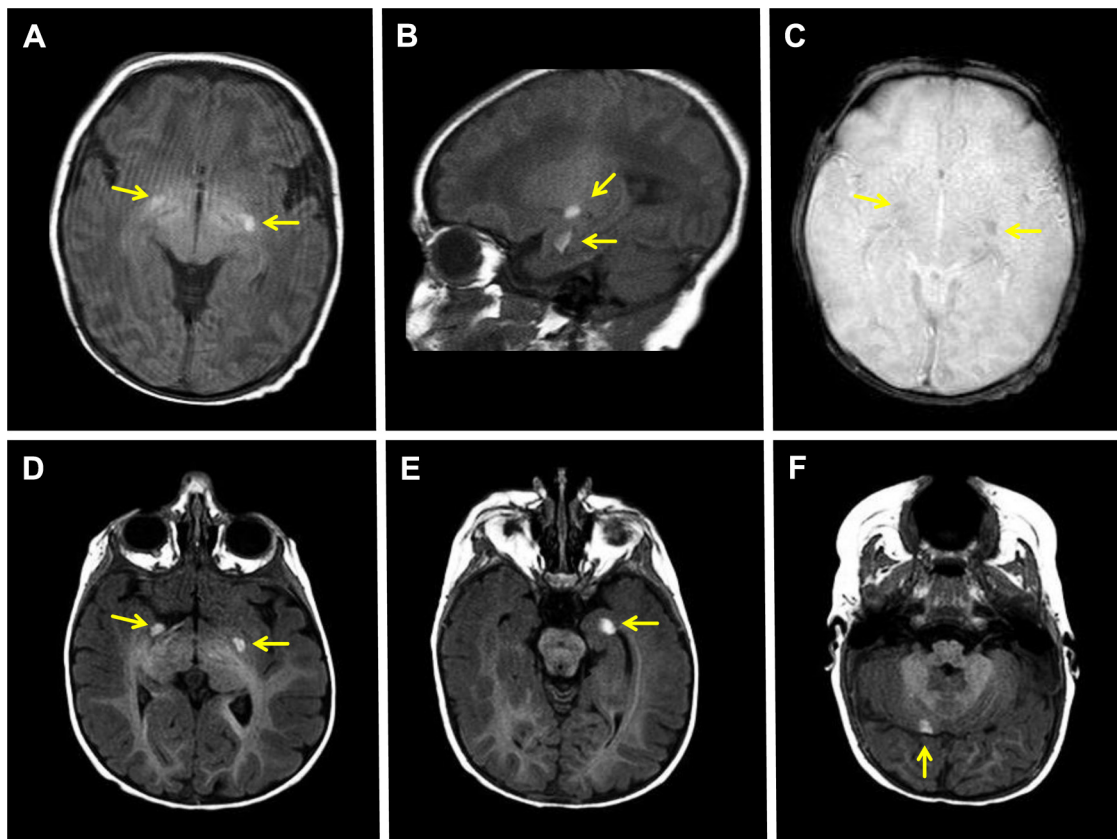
Neonatal brain MR images show multiple T1-hyperintense intraparenchymal lesions in bilateral inferior basal ganglia (A), left thalamus and left mesial temporal lobe (B). The lesions are mildly hypointense on susceptibility-weighted images (C). Repeat MR images, 3 months later, demonstrate stable T1-hyperintense lesions in bilateral inferior basal ganglia (D), left mesial temporal lobe (E), and right cerebellum (F). Arrows point to the intraparenchymal lesions.
